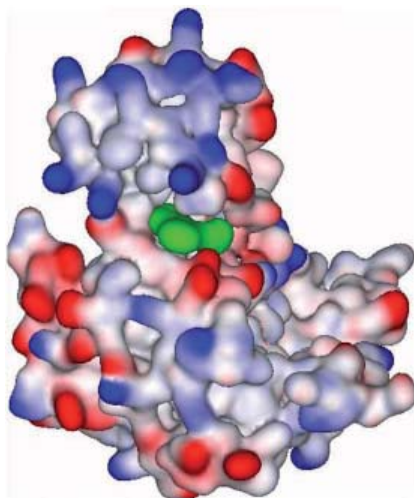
X-ray of Series 1 bound to Chk2
